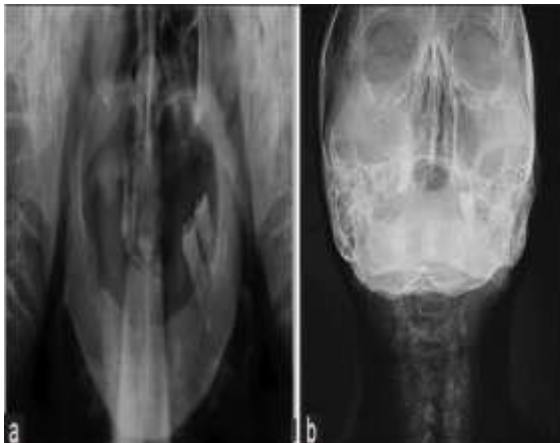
(a) Orthopantomograph, (b) PNS view
